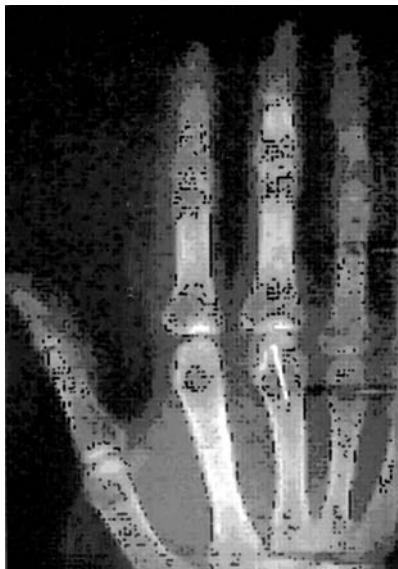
A preoperative X-ray for the same patient showing that the joint space was narrow and irregular.
